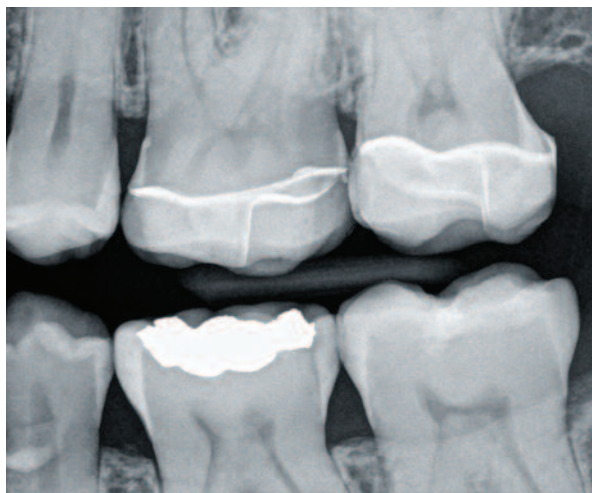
Postoperative radiographic evaluation confirmed the porcelain bond and seating.
